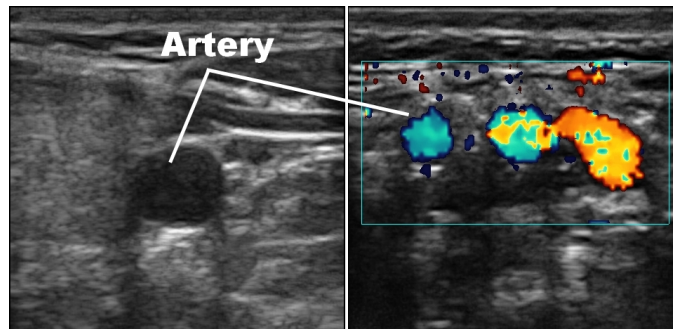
Example ultrasound images created with the intraoperative “pick-up” transducer of the carotid artery and vein. Left: B-mode image. Right: Doppler image of the arteries after bifurcation.
